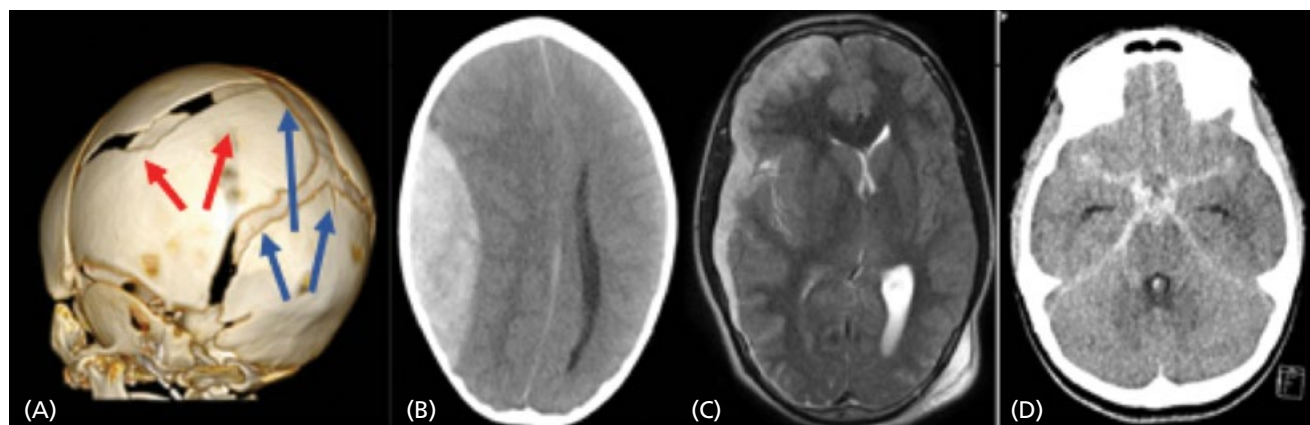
(A) Three-dimensional reconstruction of a head CT with red arrows showing a large left parietal bone fracture and blue arrows showing widening of cranial sutures. (B) Head CT without contrast showing right epidural hematoma with mass effect and midline shift. (C) T₂-weighted brain MRI showing right-sided subdural hemorrhage with mass effect and midline shift. (D) Head CT without contrast showing subarachnoid hemorrhage.
